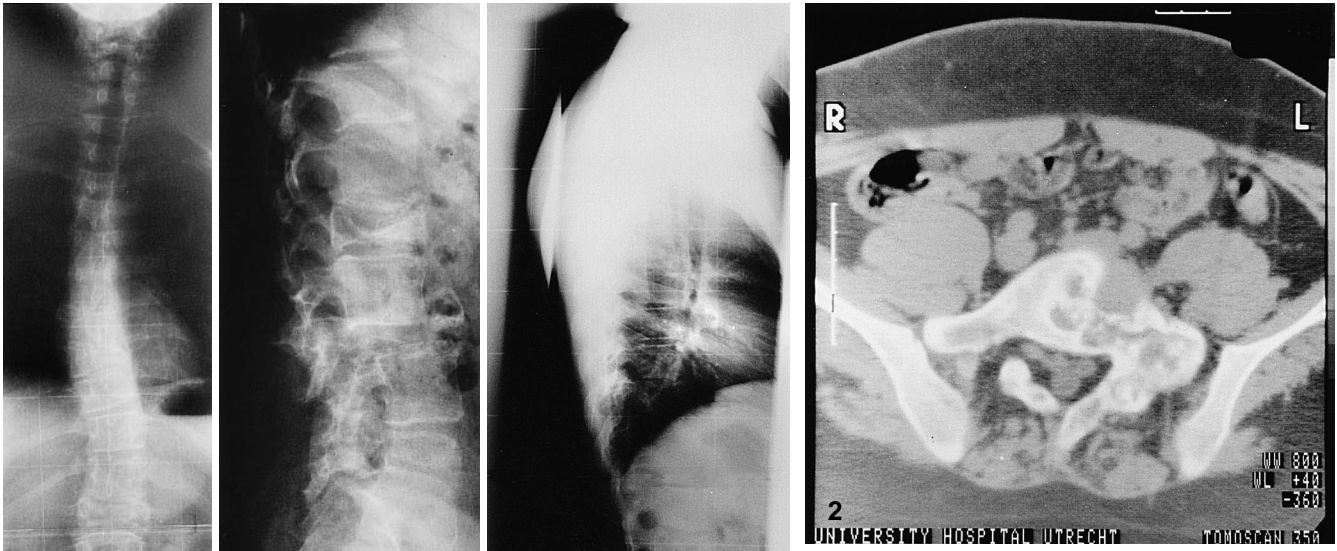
(May 1990.) Preoperative roentgenograms (A antero-posterior, B, C lateral) demonstrate fractures at multiple levels. The Cobb angle from T4 to T10 measured 26° and from T10 to L1, 15°
